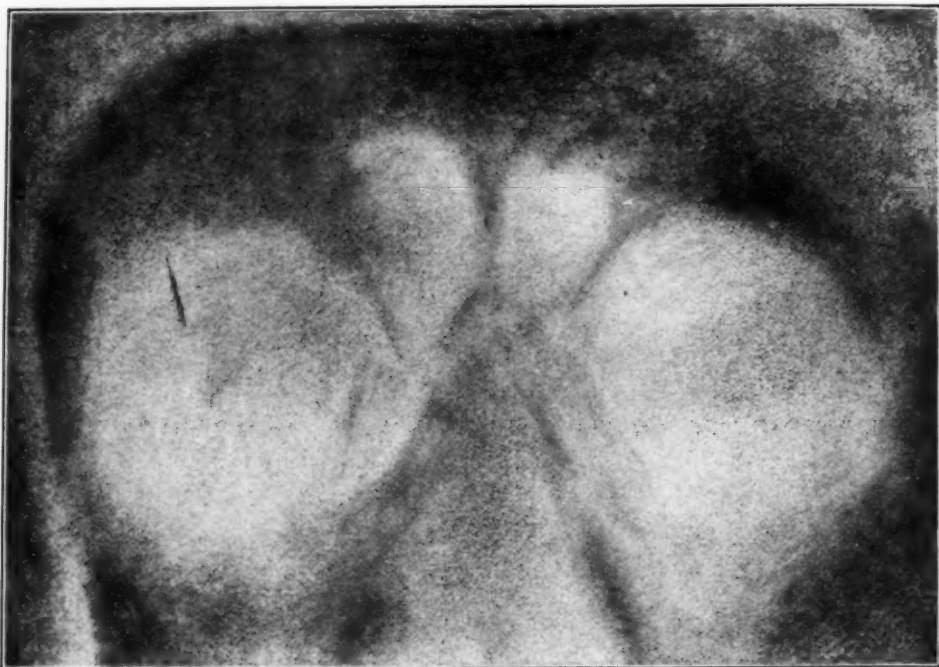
X-ray taken in the early part of 1897 of a long sliver of steel in the right eye, which was successfully removed by a magnet. Shown here for historic interest.
